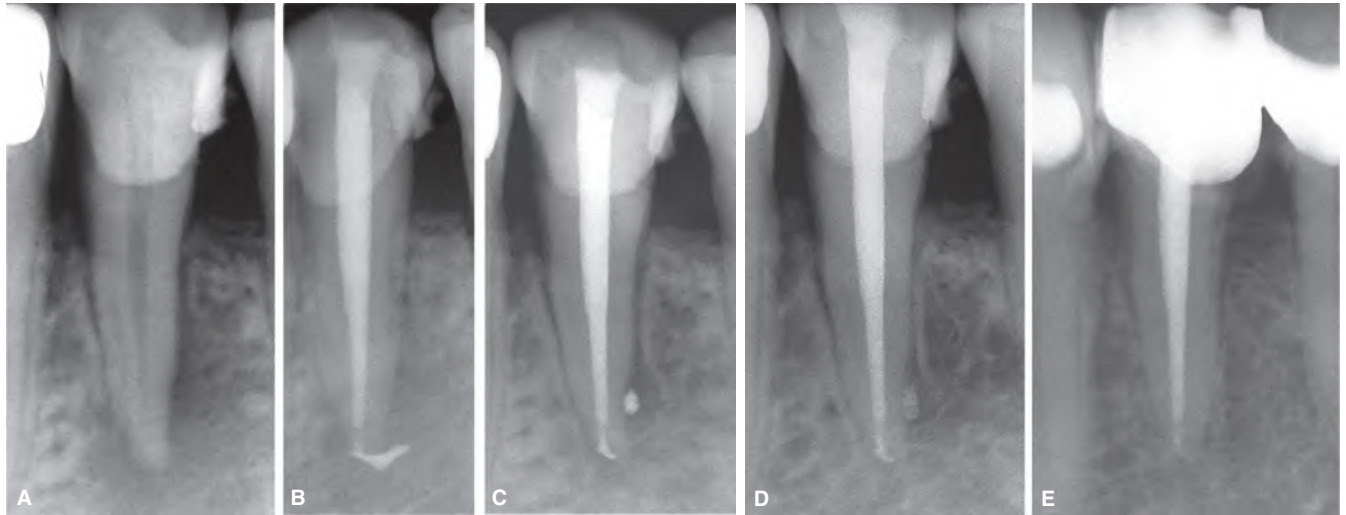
Endodontic treatment in a mandibular first premolar of a 41-year-old male. The patient reported severe pain associated with the tooth. A. Preoperative radiograph showing large periradicular radiolucency associated with the affected tooth. Vitality tests were negative. B. Immediate postoperative radiograph. C. Six-month follow-up showing marked reduction in size of periapical radiolucency. Persistent radiolucency surrounding sealer remnants still noticeable. D. Two-year follow-up radiograph. Further reduction in size of the periapical radiolucency is evident. The extruded sealer is less apparent. E. 11-year follow-up radiograph. The periapical radiolucency has resolved and the extruded sealer has disintegrated. The patient is asymptomatic and the tooth restored to function.
